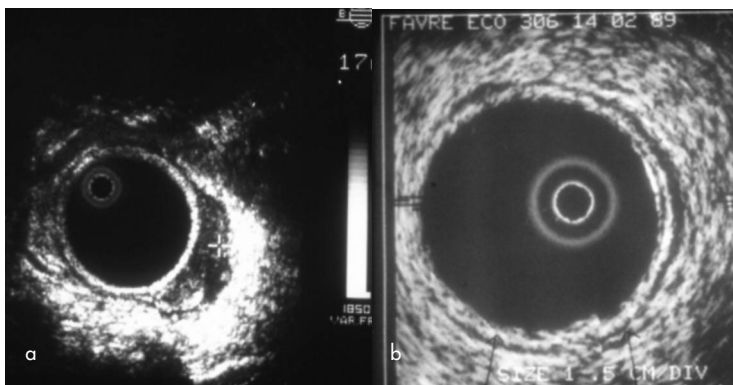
a. Intra-anal ultrasound scan showing T2 tumour. b. Intra-anal ultrasound scan showing complete response 3 months following contact local radiotherapy.
